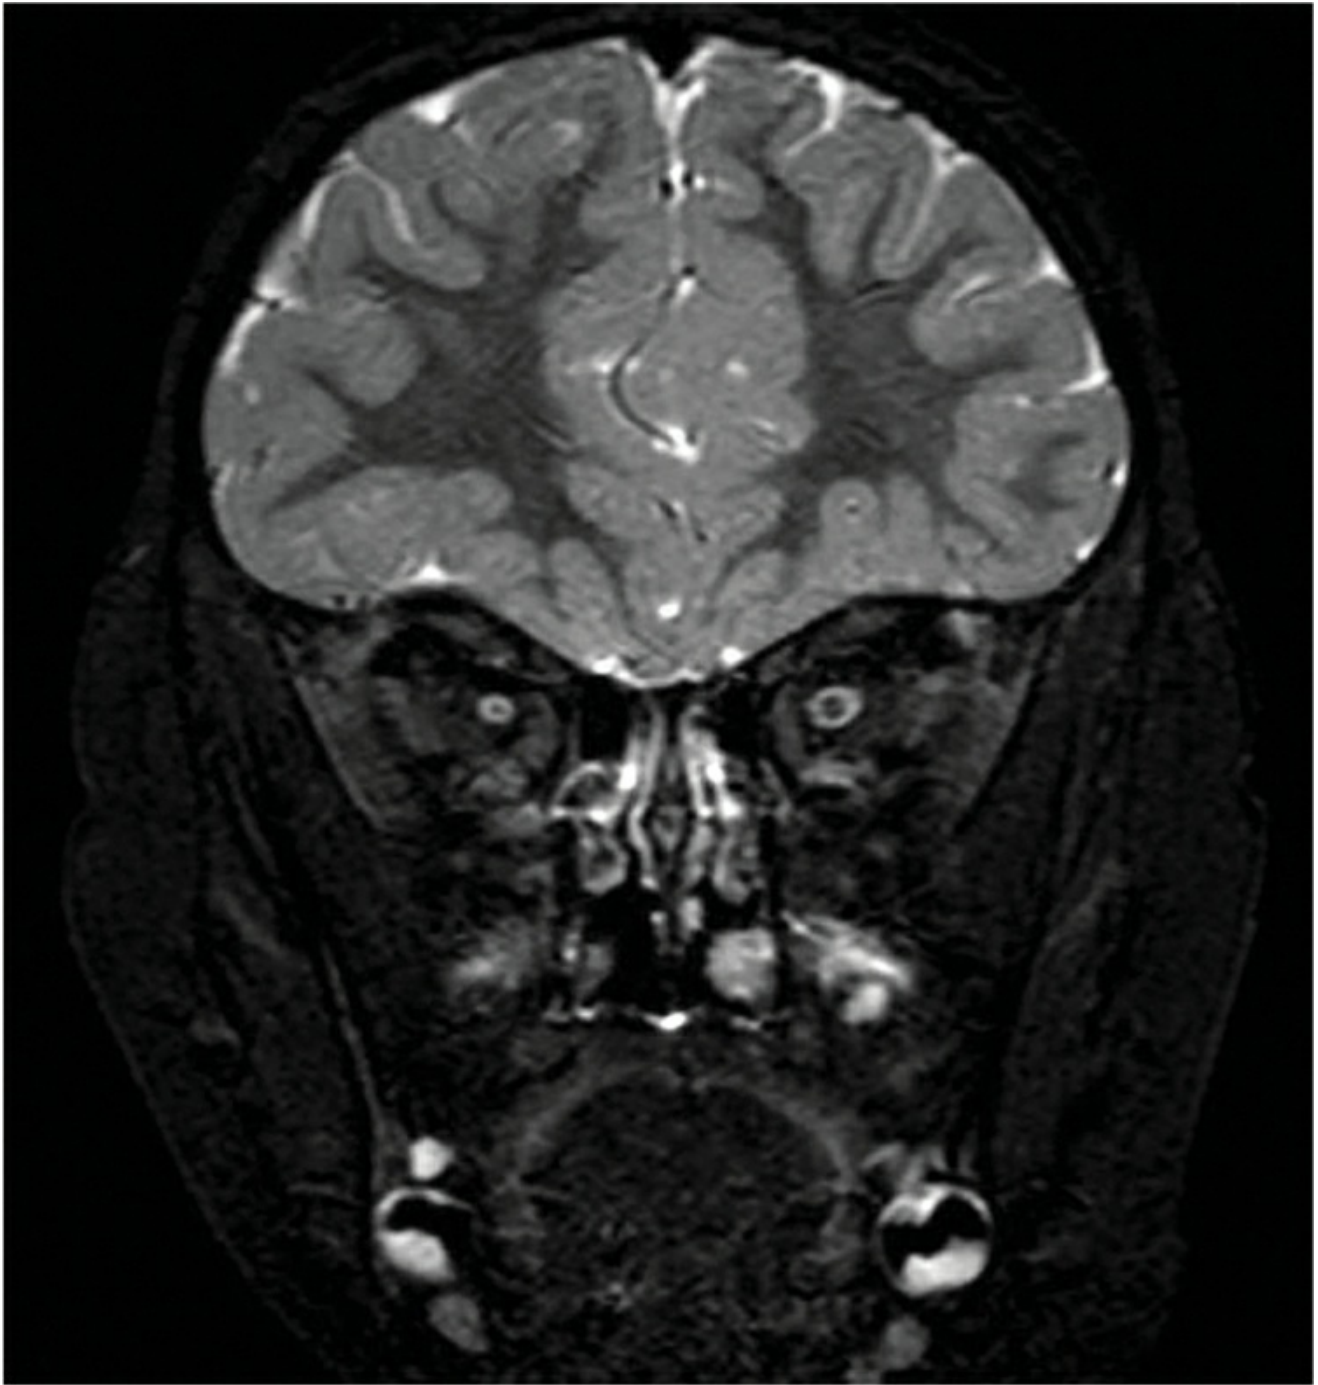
Coronal T2-weighted MRI scan of the orbits: the right optic nerve is smaller and more T2 hyperintense than the left optic nerve. (Courtesy of Jane L. Weissman, MD.)
